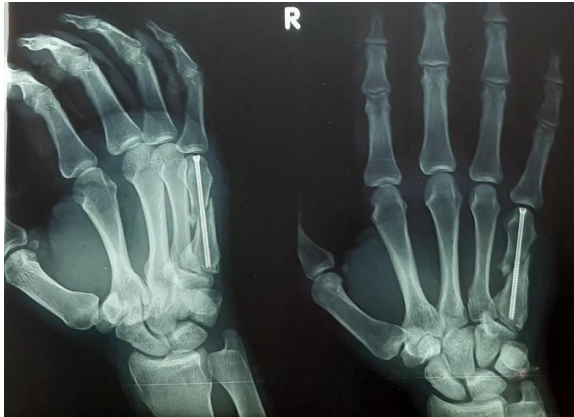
Two weeks follow up x-rays
